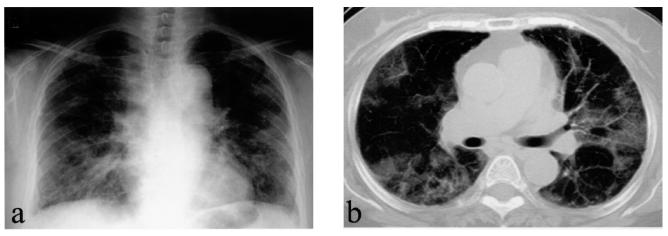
Chest radiograph (A) and CT on admission (B). Radiograph reveals diffuse patchy opacities in both lungs, and CT scan shows subpleural interstitial reticular patterns and superimposed ground-glass opacities, which were most prominent in the lower lungs.
